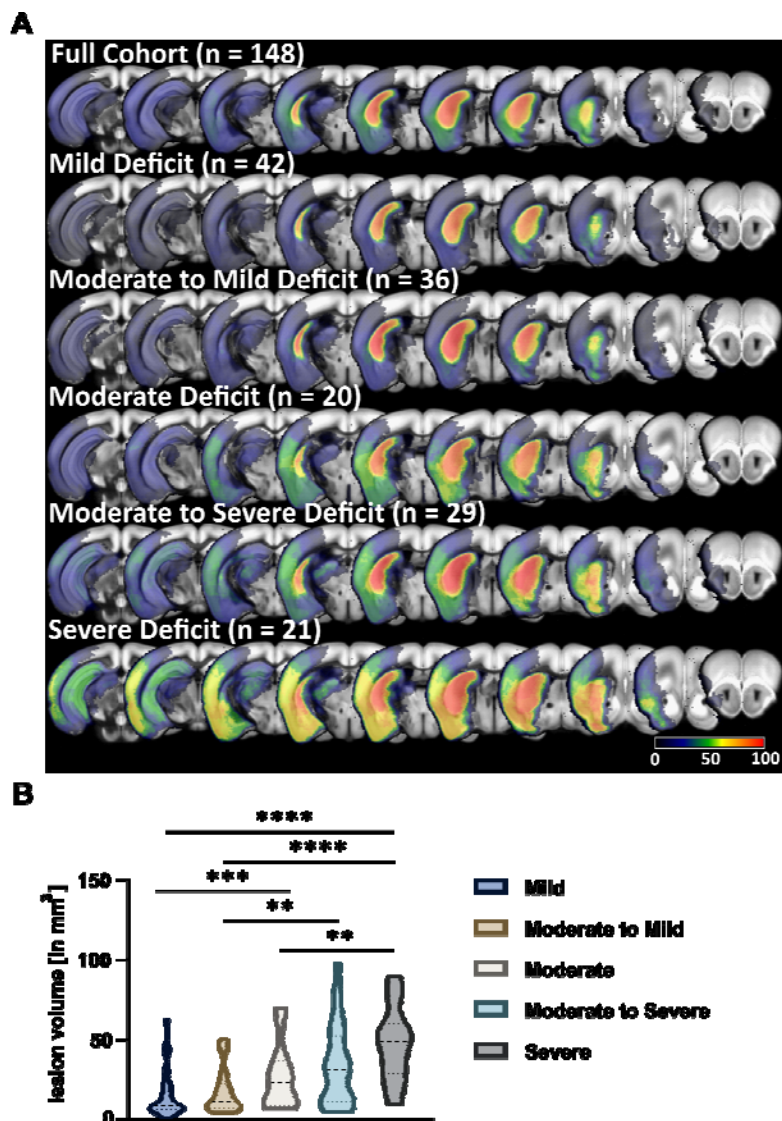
MRI characterization of lesion volume and location.
